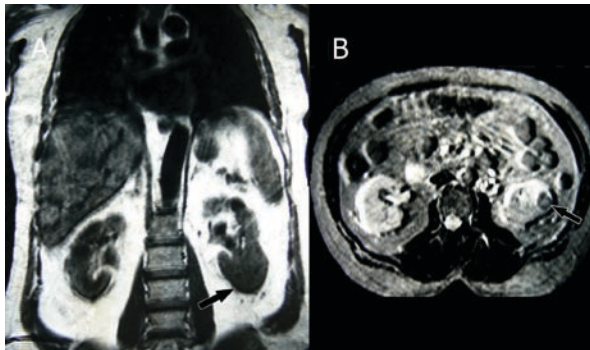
The tumor was detected on T1 (B) and T2 (A) weighted magnetic resonance images revealing a well-defined solid tumor arising from the lower pole of the left kidney without any signs of ossification.
